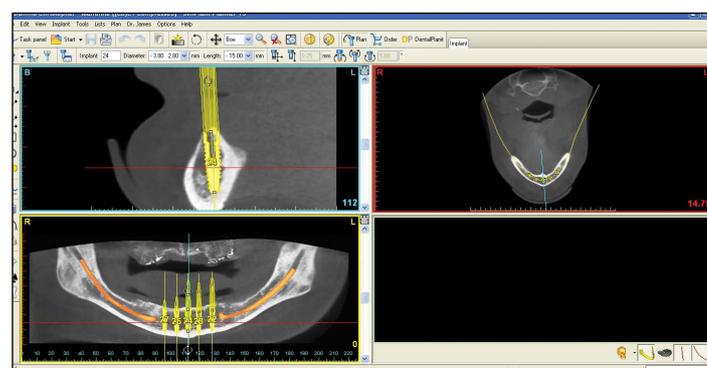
CBCT reformatted for mandibular implant rehabilitation.
